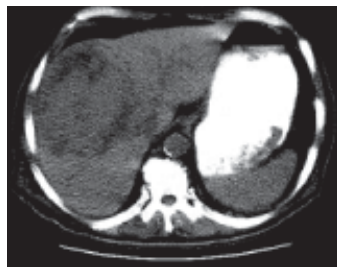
Large HCC on plain CT
